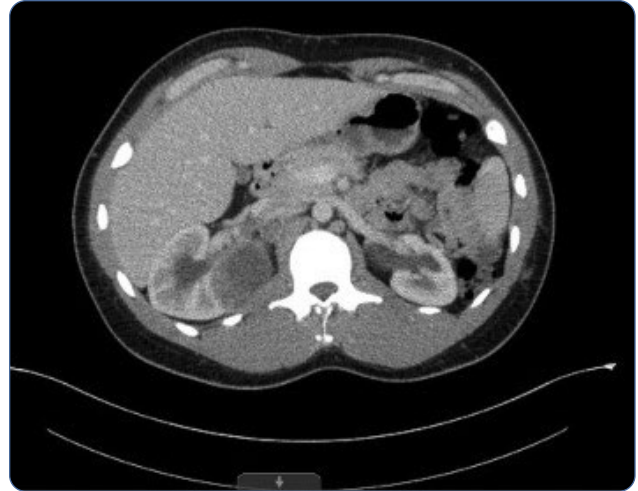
CT abdomen/pelvis demonstrating right renal mass and adenopathy.
